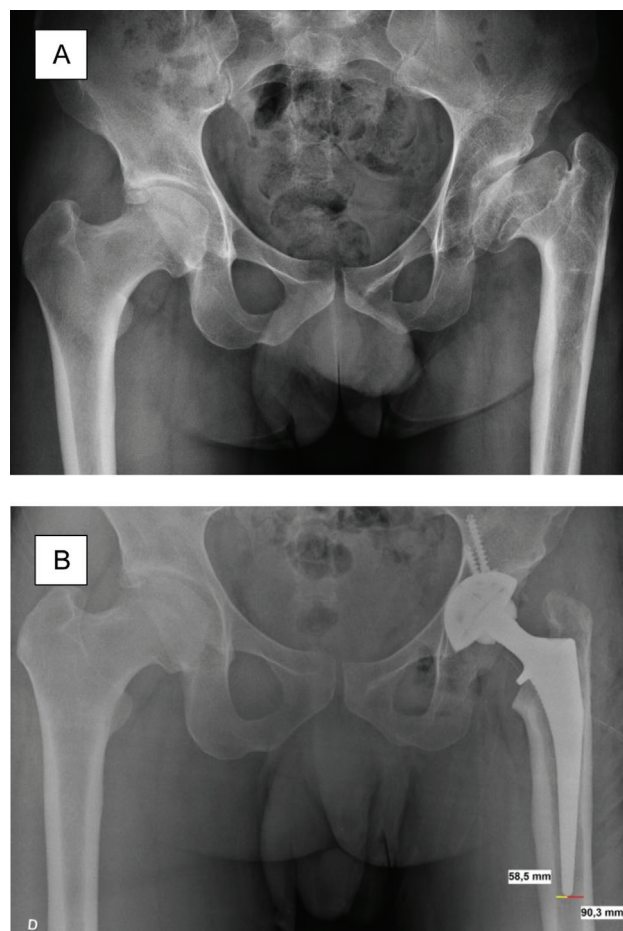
Evaluation of the femoral component position in relation to the femoral canal (centralization) in anteroposterior radiographs of the hip. (A) Preoperative period. (B) Immediate postoperative period.
